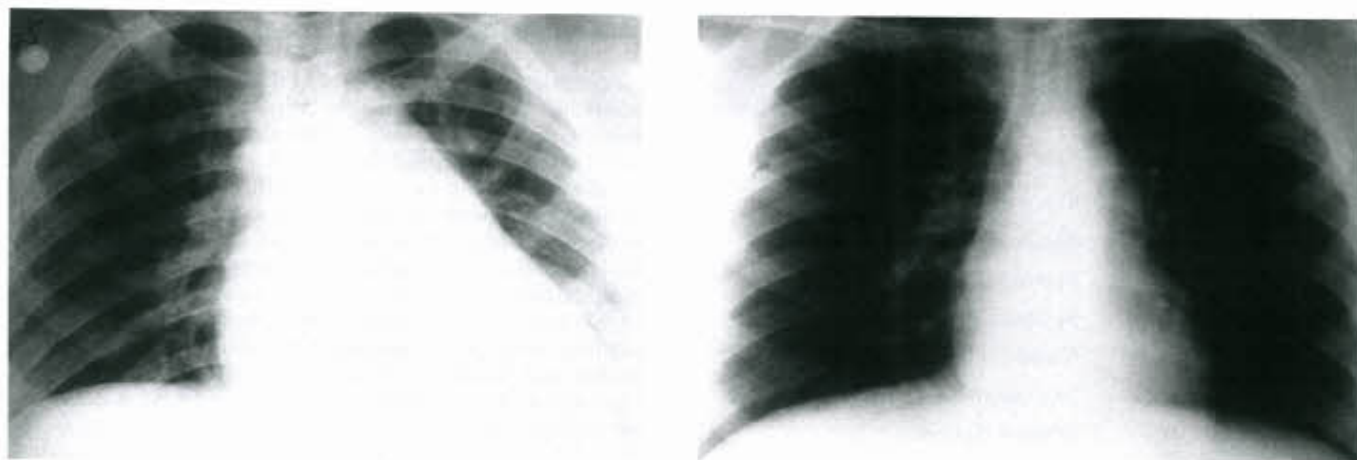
Chest radiograph in a child with acute myocarditis. Left: Initial radiograph demonstrating cardiomegaly and increased pulmonary vascular markings consistent with pulmonary edema. Right: Radiograph obtained 6 months after initial presentation demonstrates normalization of heart size and lung markings.
